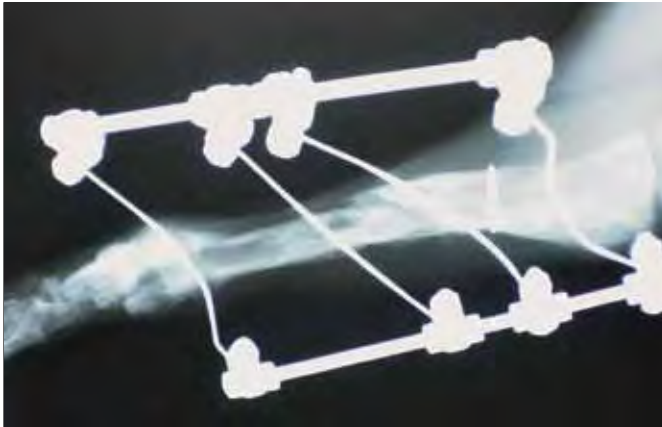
Xray shows fully functional healing which had held for 8 months so author expects no problems.
